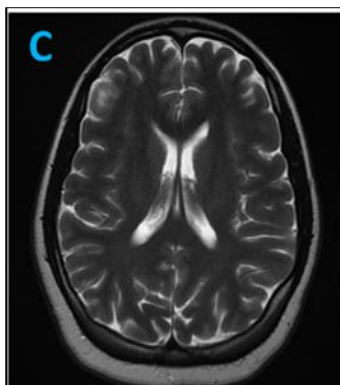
Magnetic resonance imaging (MRI) with/without intravenous (IV) contrast of the brain: demonstrates normal anatomy and no evidence of pathology, including unremarkable ventricles and subarachnoid spaces in size for the patient's given age, nor evidence of mass effect, midline shift or abnormal extra-axial fluid mass; additionally, there is no evidence of abnormal enhancement following intravenous contrast administration
